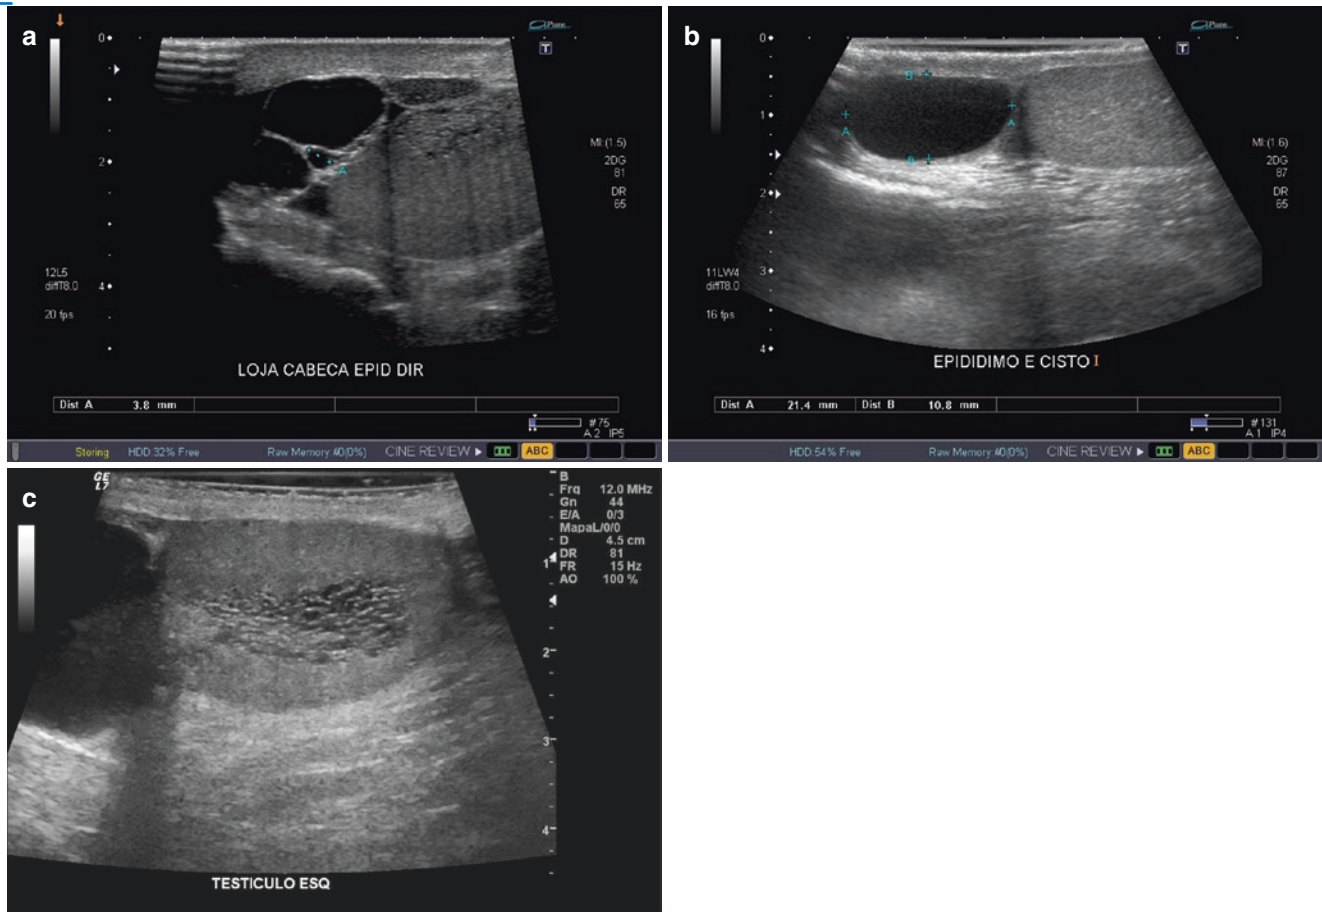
Cyst in the epididymis head. (a) B mode ultrasound shows septated cyst in the epididymis head. (b) B-mode ultrasound shows simple cyst in the epididymis head. (c) B mode ultrasound shows dilated rete testis
